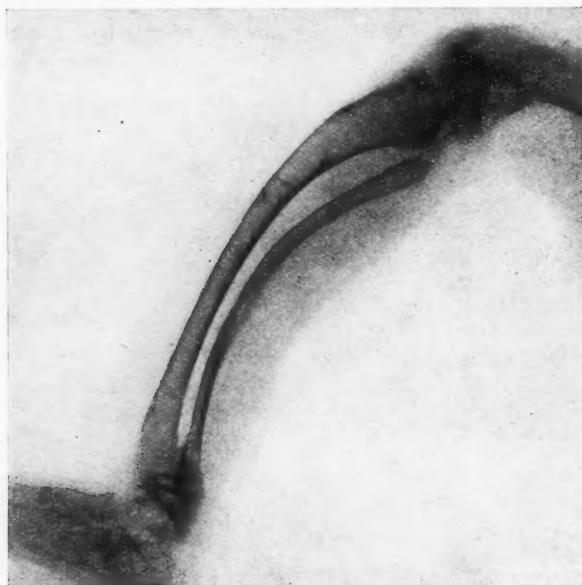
Osteomalacia. x-Ray of left leg of patient shown in Fig. 111.
